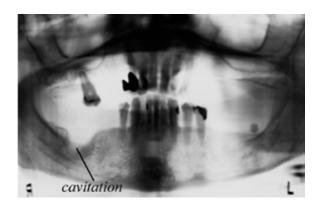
Panoramic X-ray showing large cavitation at lower left
